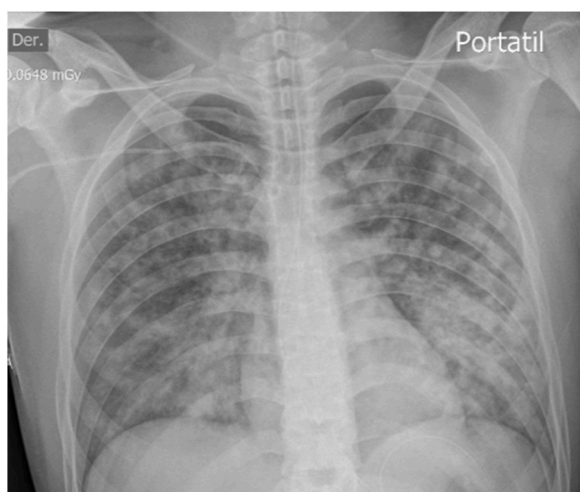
Chest X-ray on admission showed symmetrical lung fields with multiple alveolar opacities of nodular appearance with a tendency to coalescence on both lung bases.
